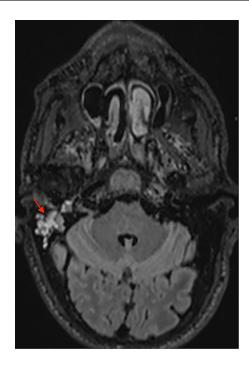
Axial FLAIR images showing right otomastoiditis (red arrow).
